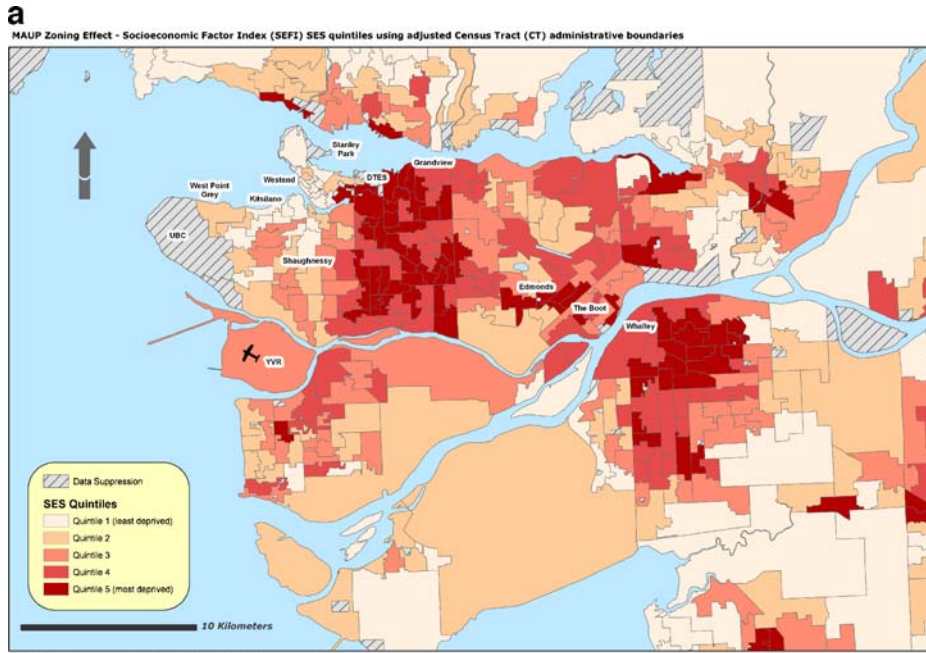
(a) Zoning Effect of MAUP using the SEFI index for the Vancouver CMA at the Census Tract (CT) extent; (b) The original Census Tract (CT) extent of SES distributions using the Socioeconomic Factor Index (SEFI).
